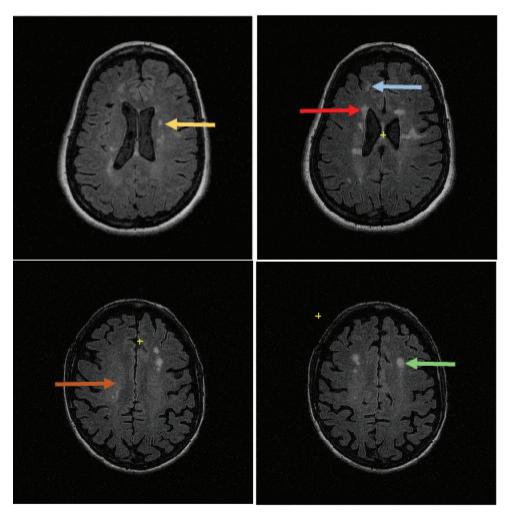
Typical Presentation of White Matter Lesions of Two Patients of the Study. Lesions are detectible by the fluid attenuated image (FLAIR) sequence; ovoid lesions perpendicular to the lateral ventricles are called Dawson fingers (yellow arrow), periventricular lesions (red arrow), juxtacortical lesions (light blue arrow), dirty or diffused white matter (rusty color arrow), and lesions on the U-fibers reaching the cortical area (green arrow).
